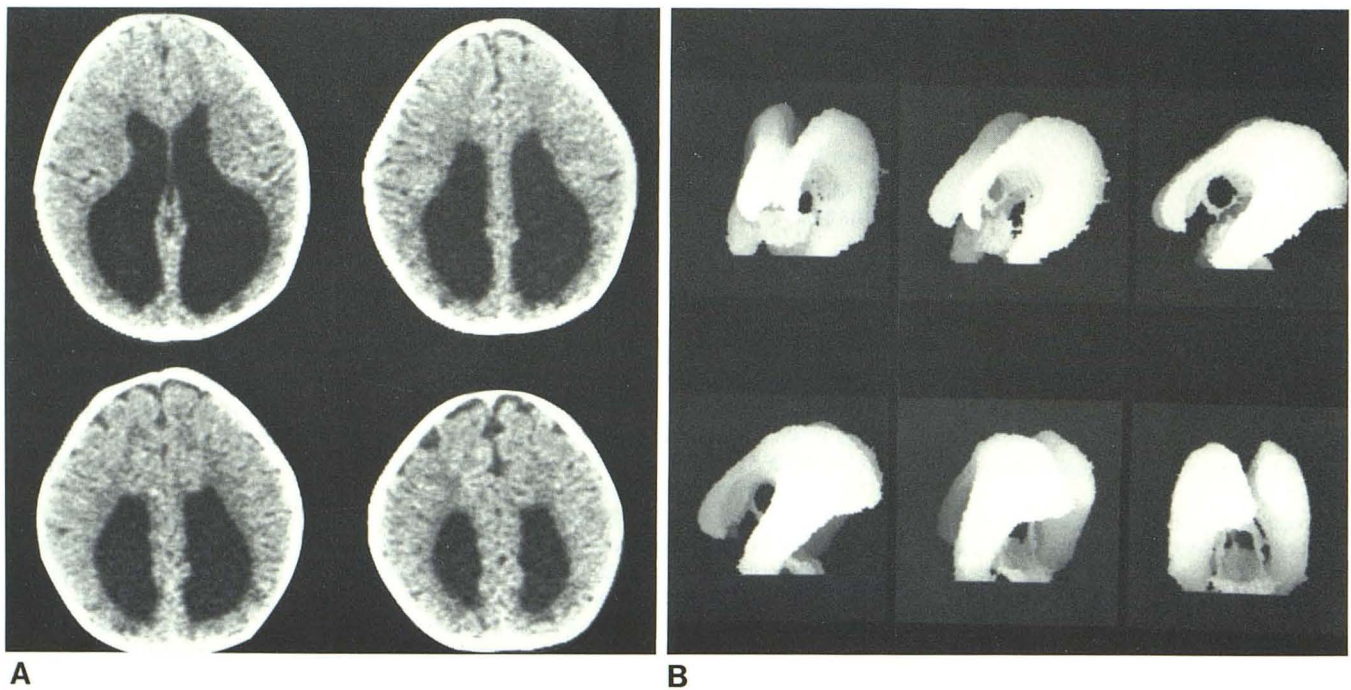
Case 1. Colpocephaly. A, Axial scans through brain show lateral ventriculomegaly with disproportionate enlargement of occipital poles. B, 3-D CT reformations about Z axis show ventricular enlargement proceeding from
